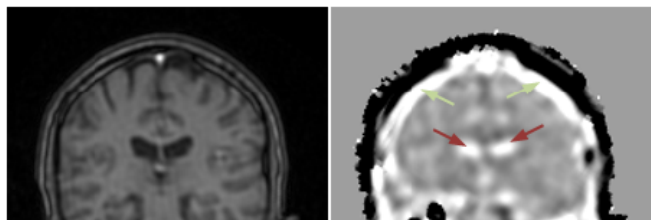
Initial in vivo results. Left: anatomic MR image of the volunteer's head. Right: reconstructed conductivity. A clear contrast between ventricular / sub-cranial CSF (red / green arrows) and the surrounding gray / white matter is visible.
